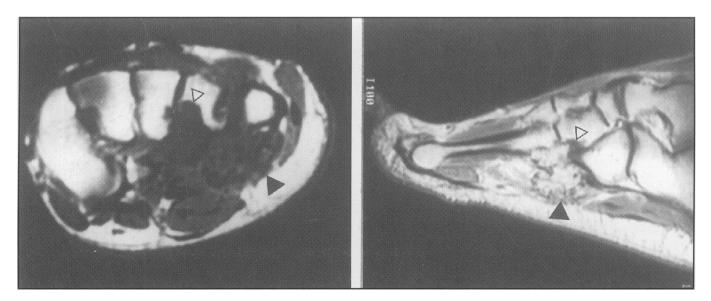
(a). Coronal view Tl weighted MRI Low signal tissue is seen adjacent to the base of the 4th and 5th metatarsals (closed arrow head); it has the same signal strength as the surrounding muscle. Within this region there are multiple foci with very low signal in keeping with calcification. The low signal soft tissue is seen eroding into the plantar aspect of the 4th metatarsal (open arrow head).
